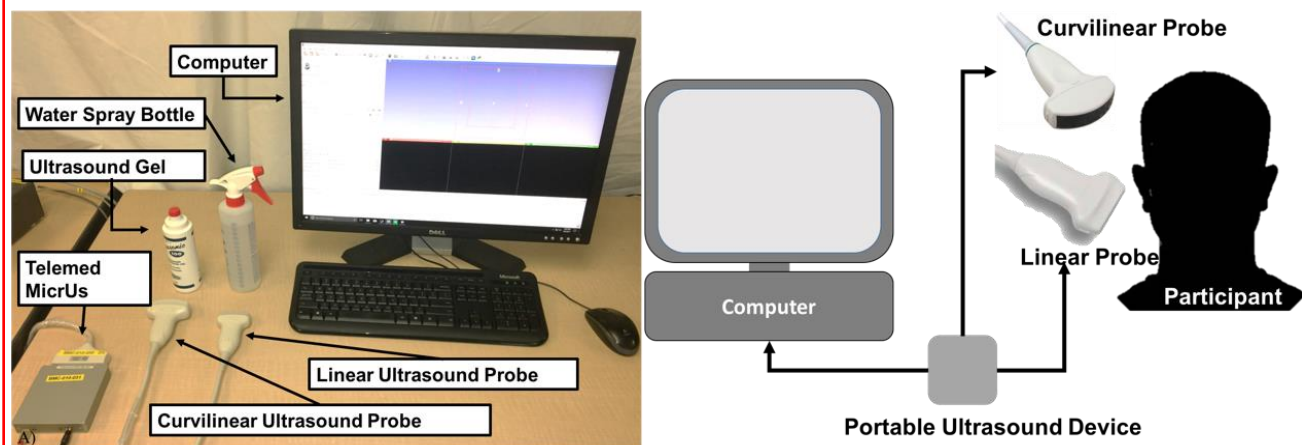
A) Experimental setup and equipment for performing ultrasound scans on participants, B) System set up for the experiment.
